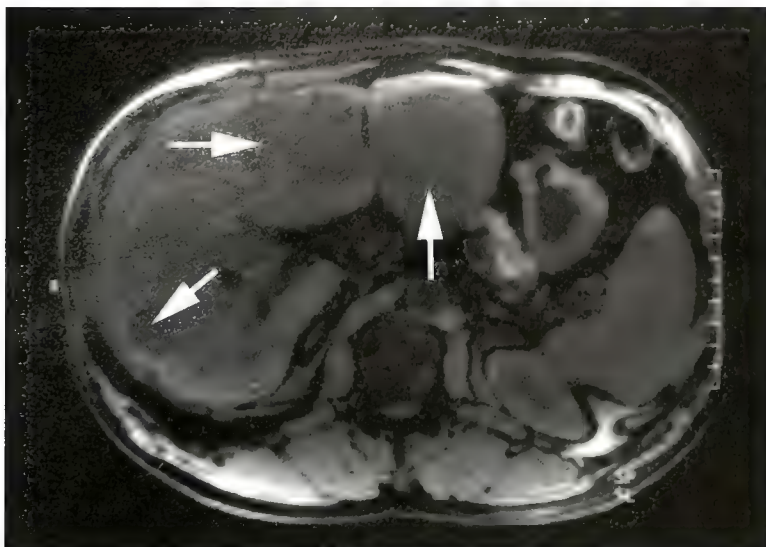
Pre-gadolinium T1-weighted axial image with fat-suppression demonstrates three low attenuation lesions in the liver (arrows).
